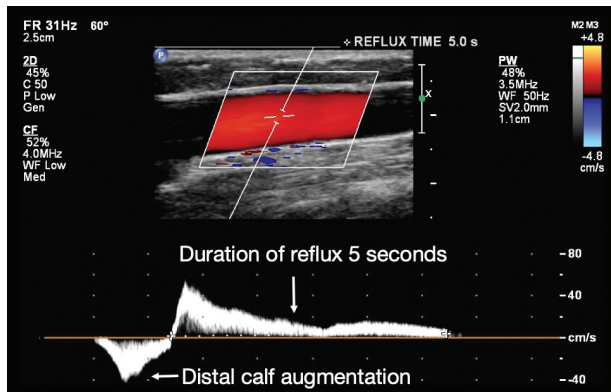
Pulsed-wave Doppler waveform demonstrates an incompetent GSV with a reflux time of 5 seconds. Waveform reflects clear delineation from the augmentation to the end of its duration. The reflux is color coded in red within the vessel lumen, coinciding with the direction of flow relative to the color bar, which is toward the transducer. The reflux waveform follows in the same direction (above the baseline).
